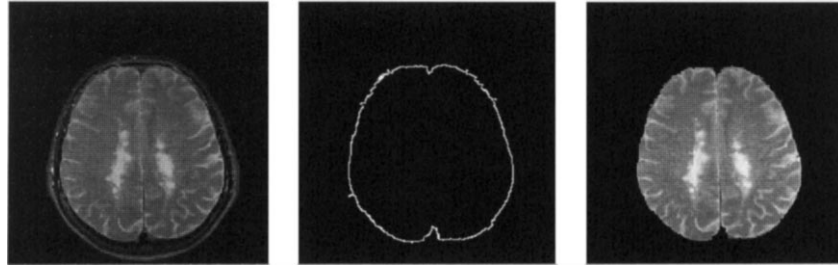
Internal cavity extraction. Left: original T2-weighted image (256×256 pixels). Middle: intracranial cavity contour. Right: region of interest representing the intracranial cavity.
